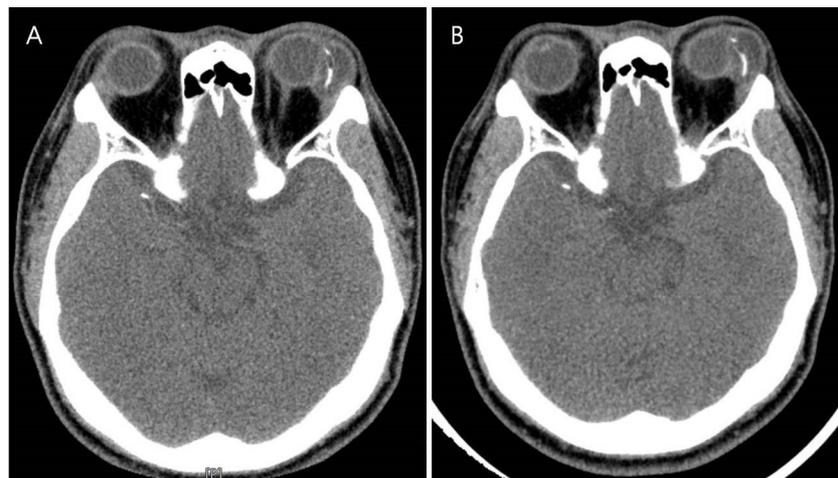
Orbit enhanced CT scan shows a 20*13.5mm septated cystic mass with septal calcified thickening at left lacrimal gland(A). 3 months later, lacrimal gland calcification is slightly resolved state.
